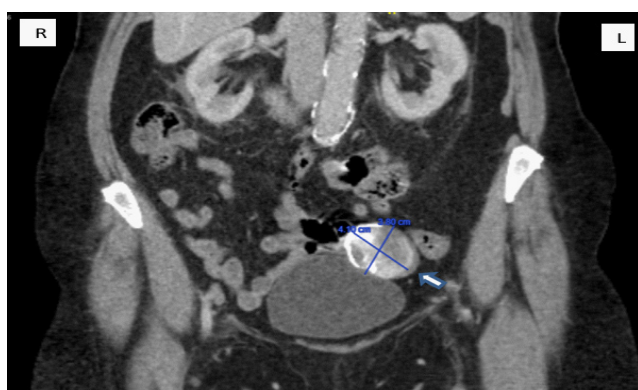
Coronal view CT Abdomen and Pelvis with contrast showing left calcified adnexal mass.
